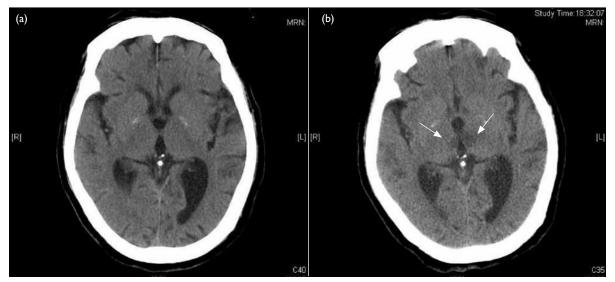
(a) The initial normal computed tomographic brain upon admission, and (b) on day 3, it shows hypodensities over the medial aspects of both thalami (arrows)
